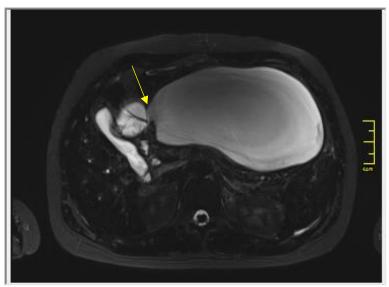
Axial T2-weighted MRI showing the fluid collection directly adjacent to the MCN-L (arrow).
